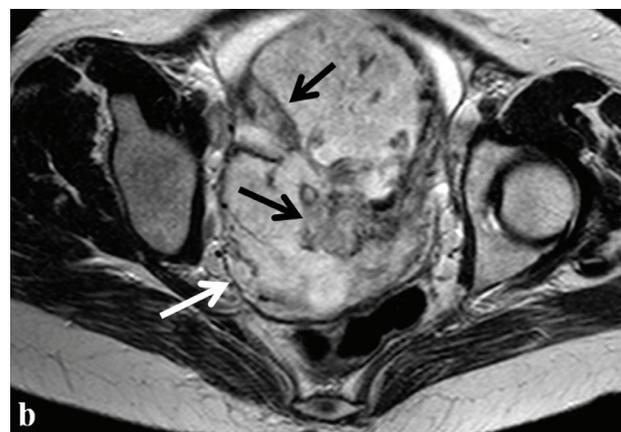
(a) Sagittal T2-W MR image of a 29-year-old patient with invasive placenta at week 34 of gestation. The placenta (P) fills the lower uterine segment and appears heterogeneous with thick dark intraplacental bands (black arrows). Extensive myometrial thinning is present as well as a focal bulge of the posterior uterine contour (white arrow)
